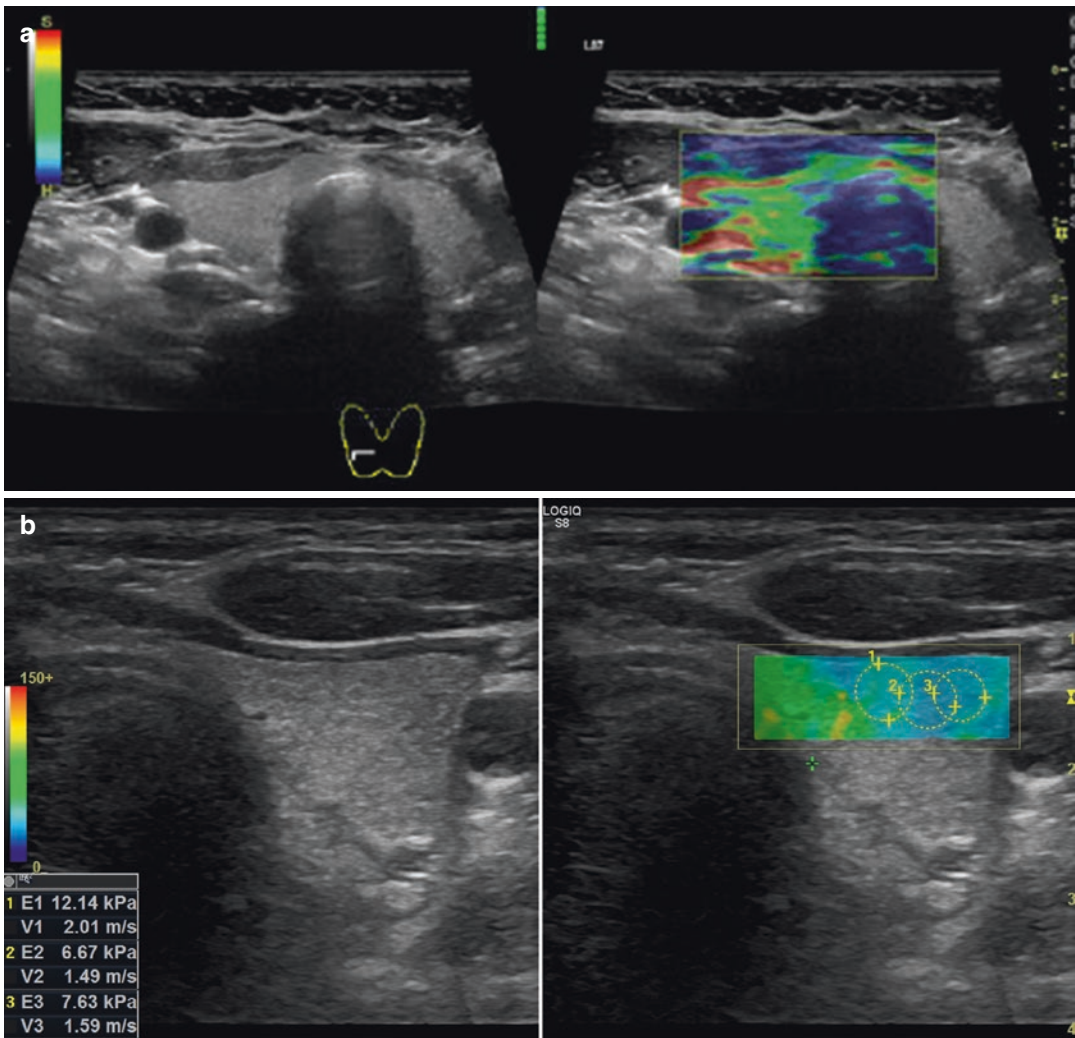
(a, b) Normal thyroid gland. (a) Strain elastography (left: transverse orientation in B-mode sonography; right: superimposed strain elastography) showing a homogeneously green/red colored (soft) thyroid lobe and blue colored (hard) trachea. (b) Shear wave elastography:
